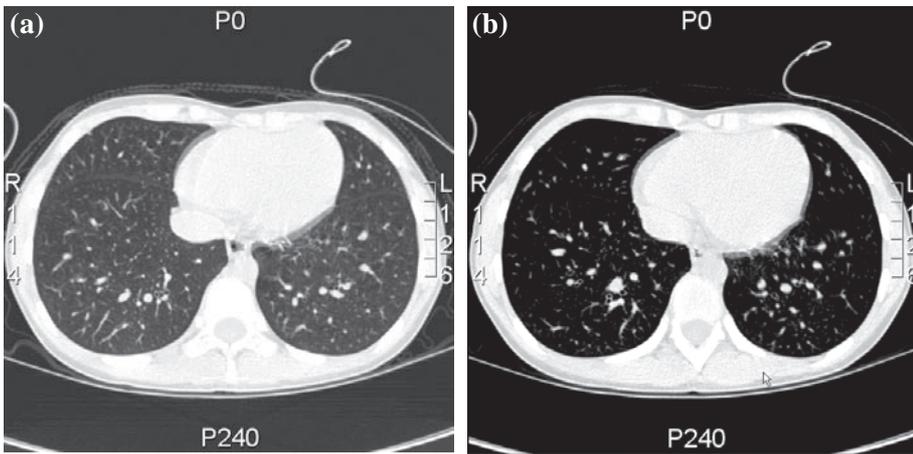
Contrast CT thorax of LPY, which showed diffuse dilatation of pulmonary vessels.
